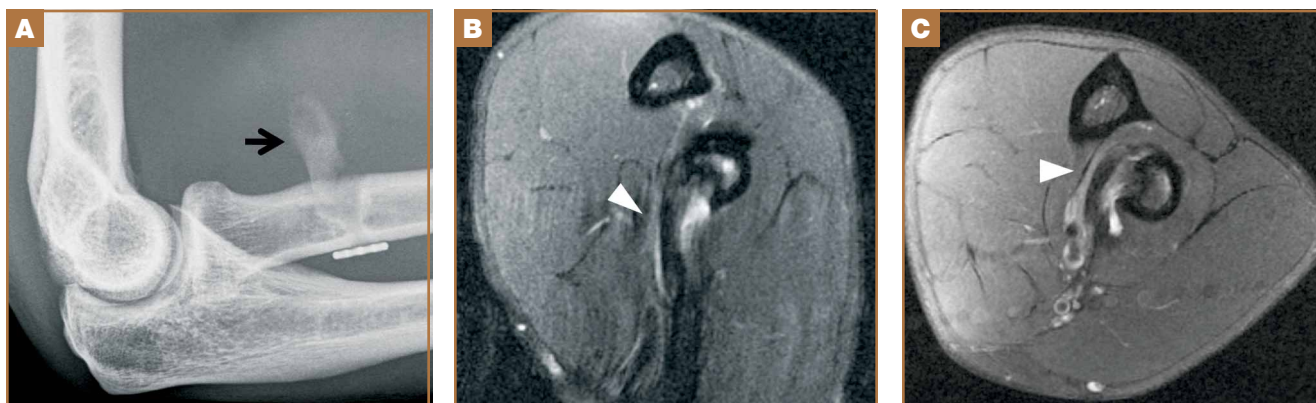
One year after surgery. (A) Lateral radiograph shows mature heterotopic bone (arrow) near radial tuberosity. In addition, axial T2-weighted magnetic resonance imaging in (B) flexed, abducted, and supinated position and (C) extended, semipronated position shows hypointense focus of bone (arrowheads) incorporated into distal tendon remnant and scar tissue.
